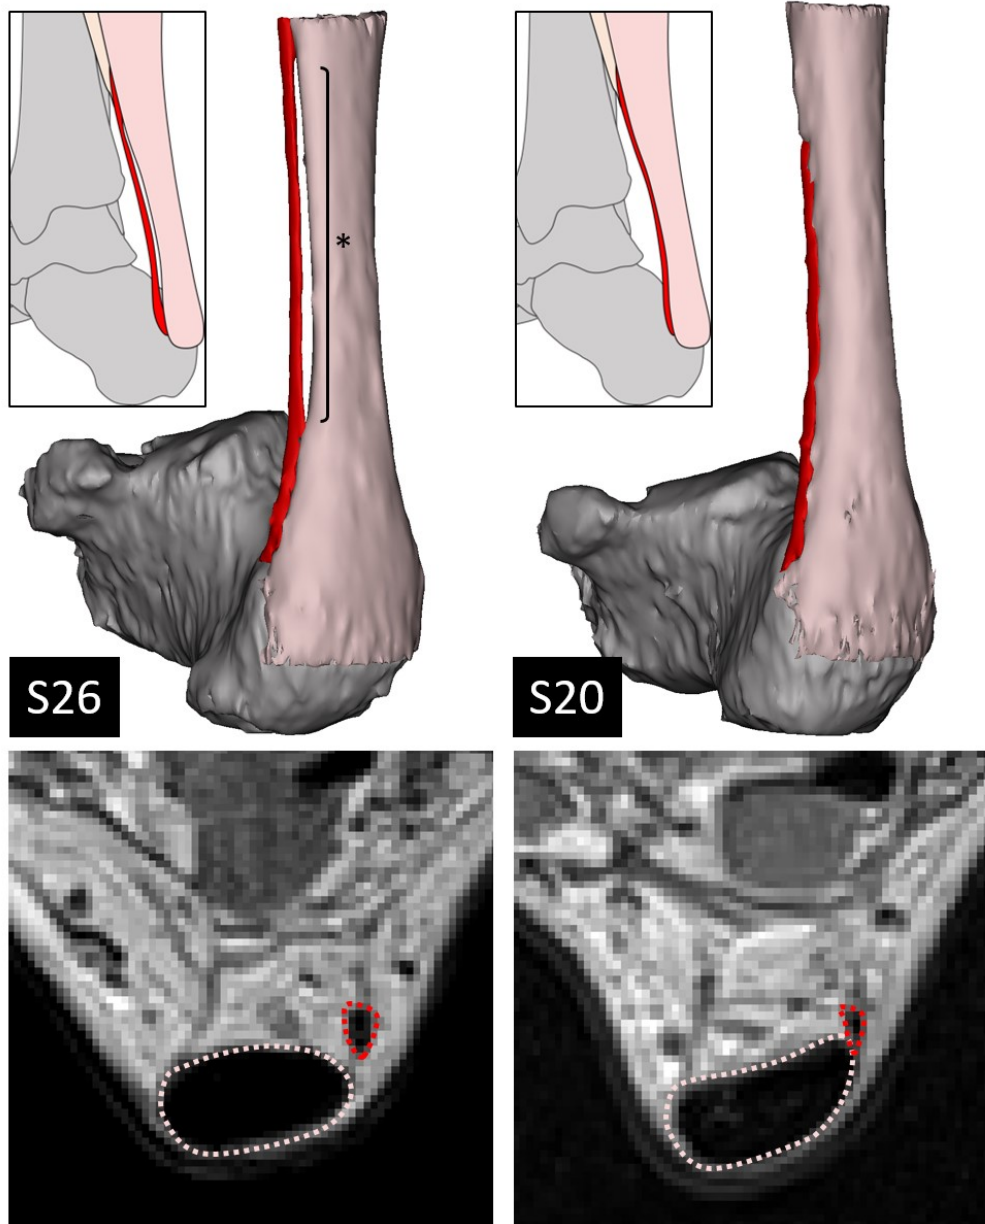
The types of plantaris tendon geometry and their presentation in MRI and ultrasound (US).
